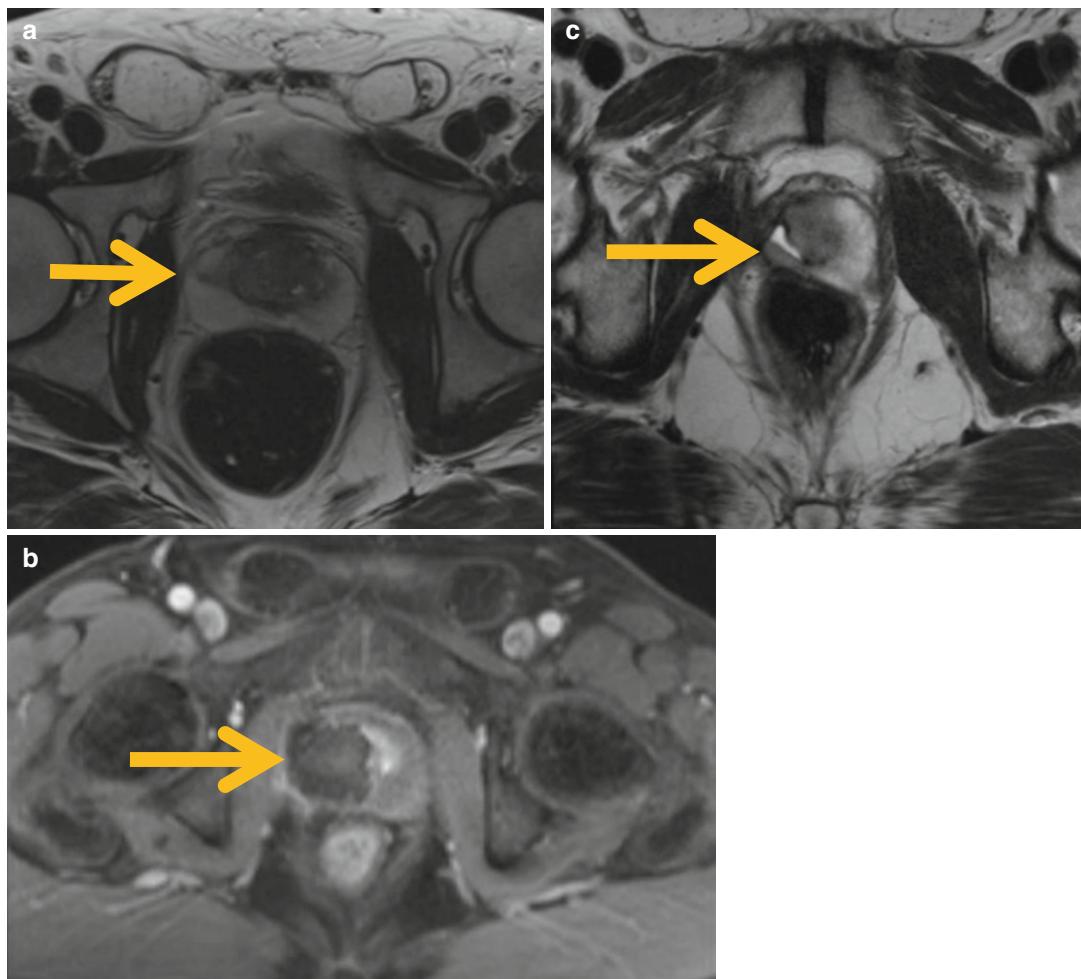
Effect of high-intensity focus ultrasound (HIFU) treatment on the prostate gland. (a) Axial T2-weighted images through the prostate show a small tumour (*arrow*) confined to the prostate in the right peripheral zone mid-gland. (b) Axial fat-suppressed T1-weighted images
